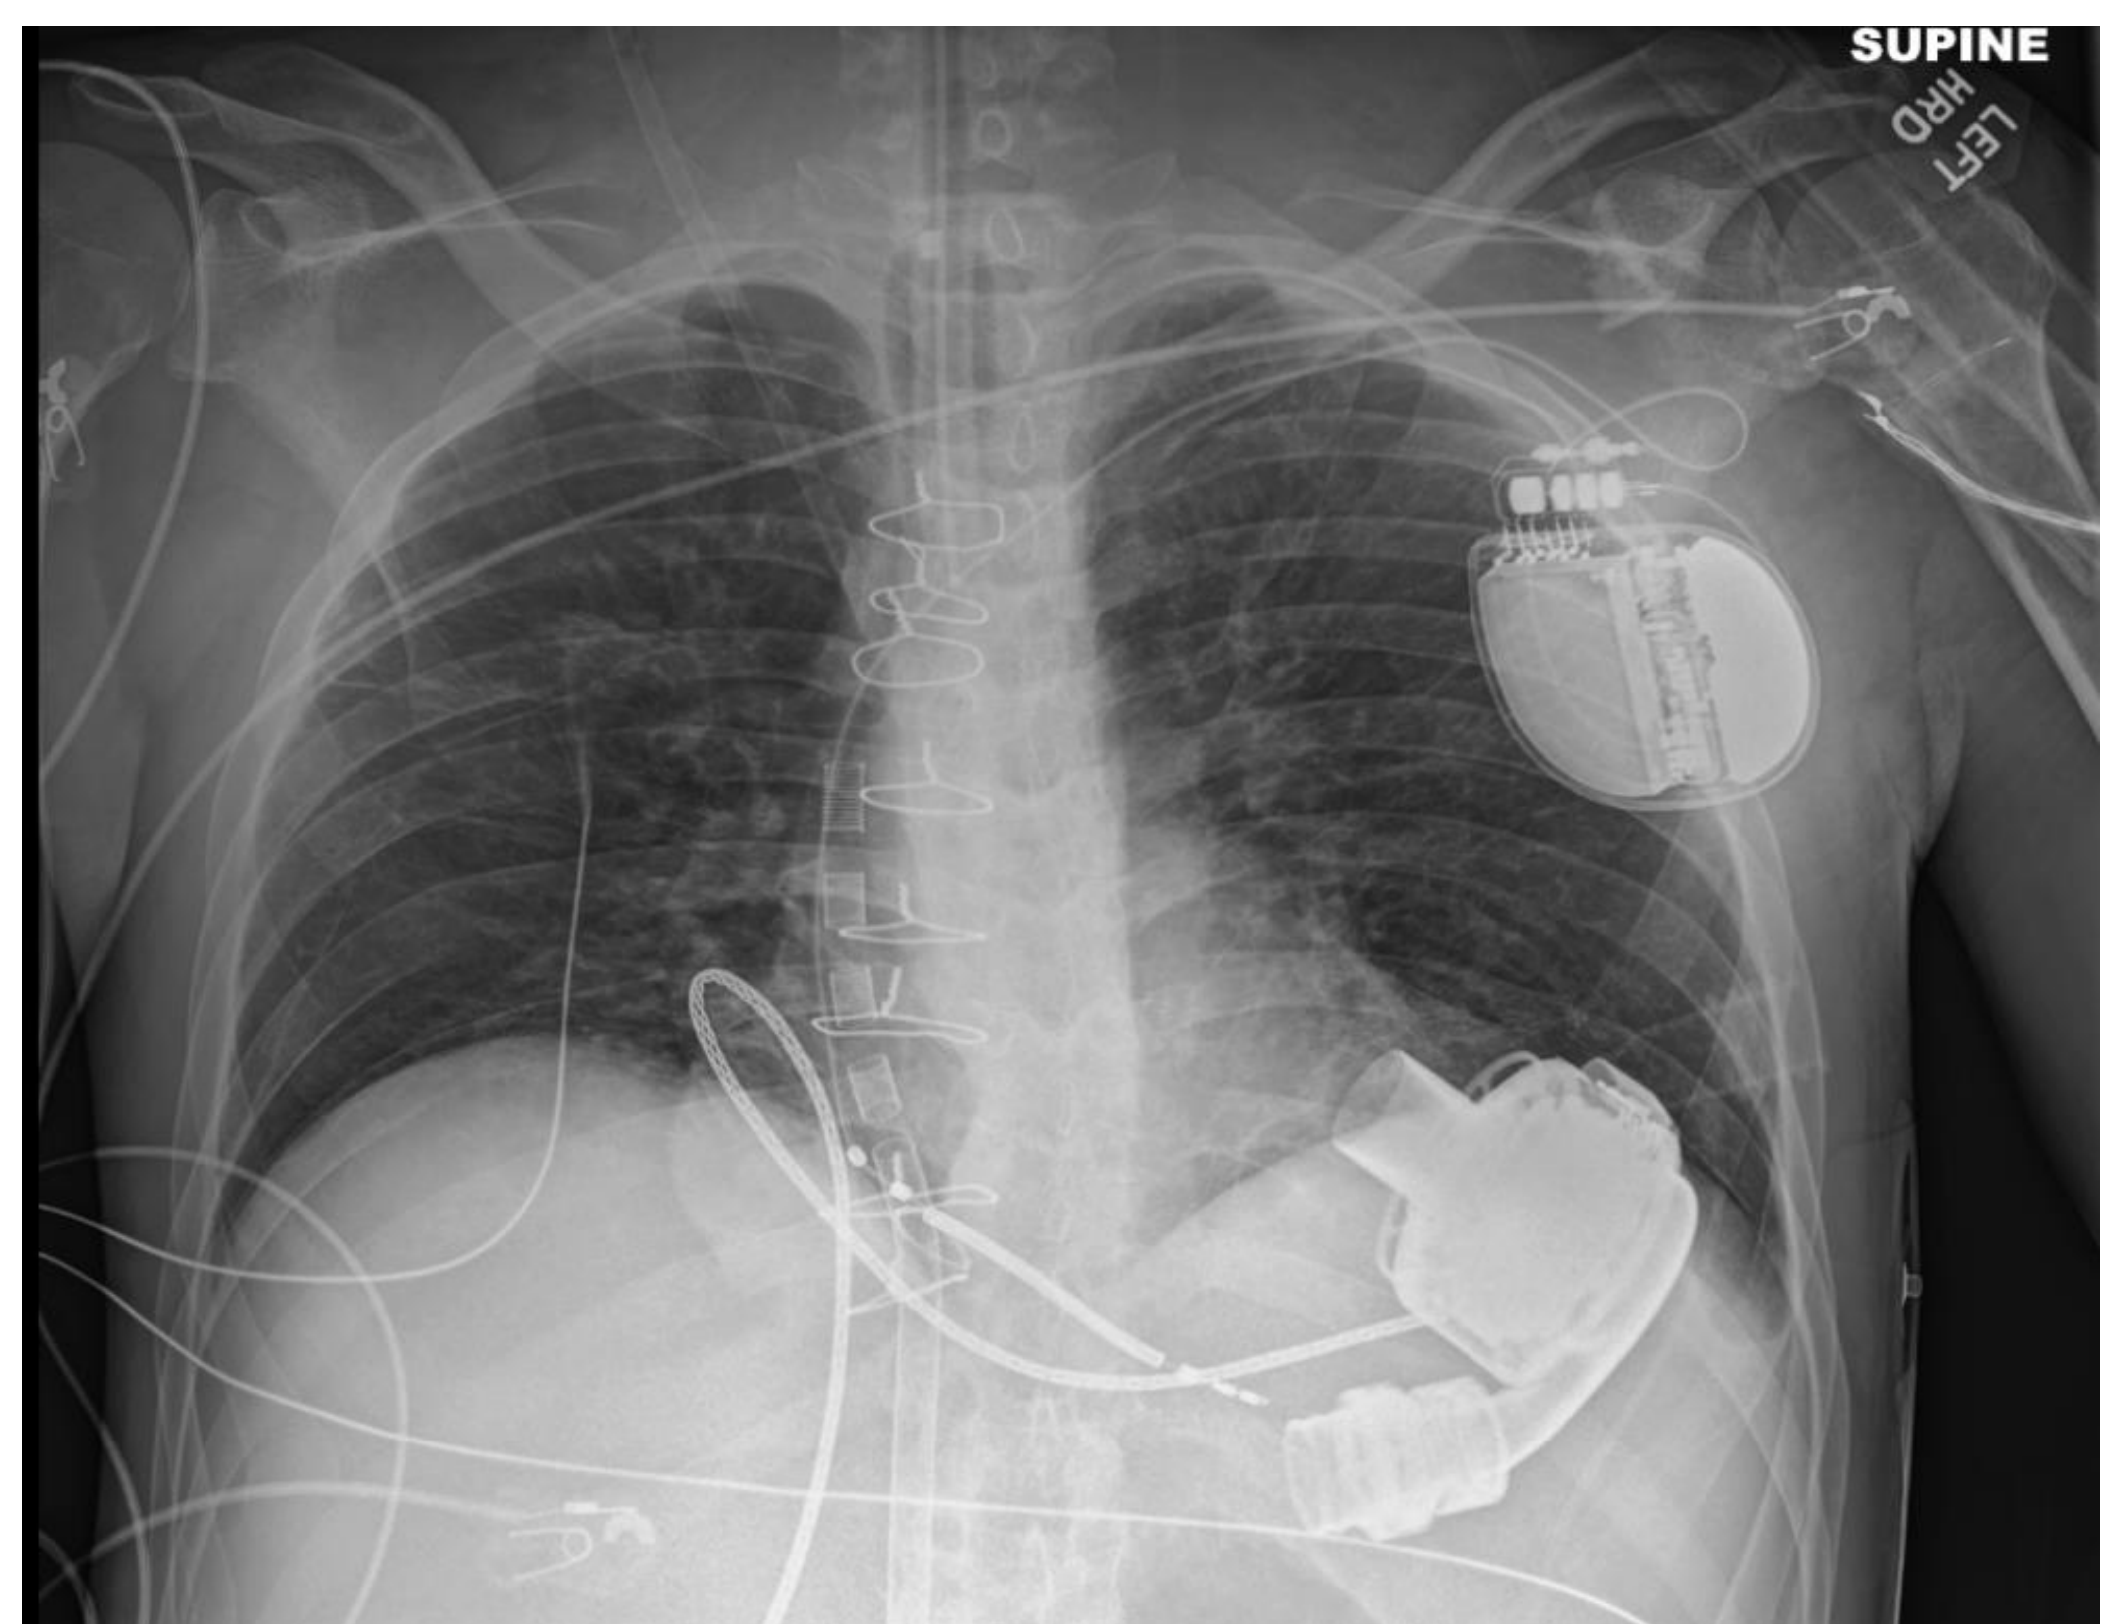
Supine chest radiograph demonstrating HeartMate III LVAD in the left upper quadrant. Endotracheal tube, ECMO cannulae, and central lines are visible, consistent with post-ECPR and intubation status.
